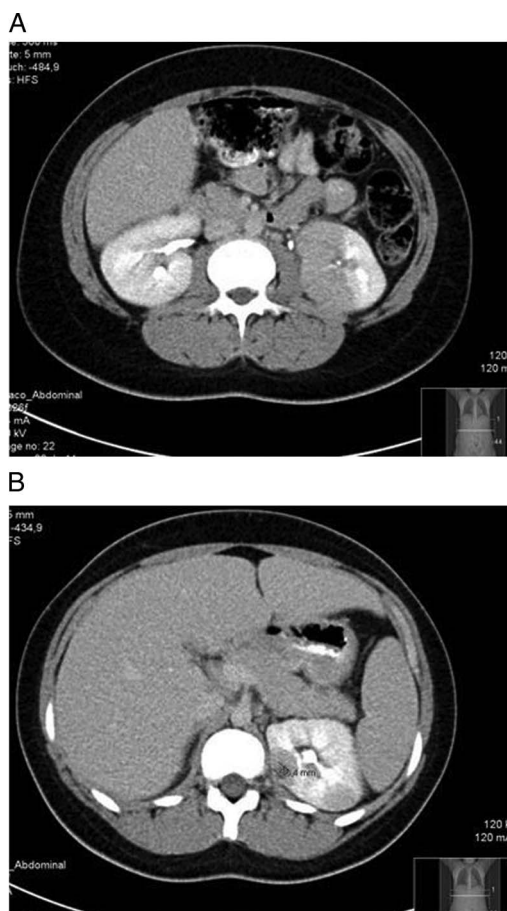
Abdominal CT scan with features of acute bilateral pyelonephritis, with a globus left kidney and multiple hypodense pseudonodular areas (A) in addition to two hypodense nodular masses with foci of reduced attenuation compatible with renal abscesses in the upper pole of the left kidney (B).
